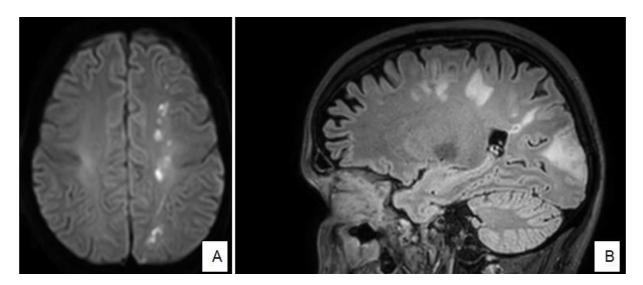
A 38-year-old young male in post-COVID-19 recovery presented with headache and altered sensorium. On MR imaging, [A] Axial DWI images showing hyperintensities in left frontoparietal lobes in watershed territories of ACA-MCA and MCA-PCA with corresponding hyperintensities on 3D FLAIR sagittal section depicted in [B]
